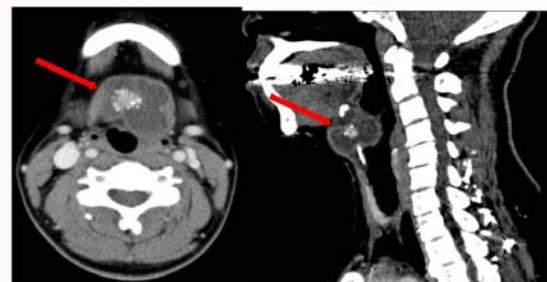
CT showed a 37 mm cystic lesion between the hyoid bones. The mass was depressing the epiglottis (arrow). It was accompanied by calcifications. There was no significant lymph node swelling.
